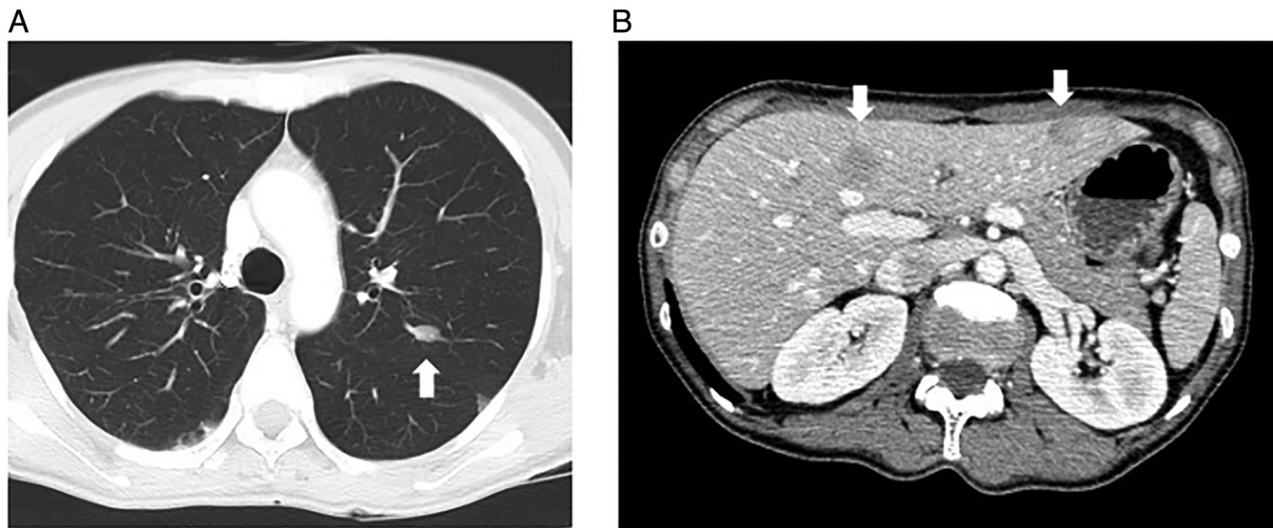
CT scan of the (A) lung and (B) liver at the time of metastasis. The metastatic lesions are indicated by white arrows.
